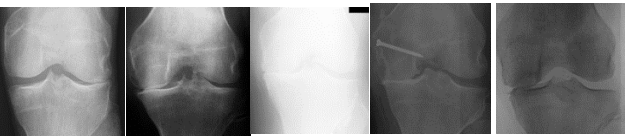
Similar Knee X-ray images corresponding to Grade 4 (Severe Osteoarthritis Class).
